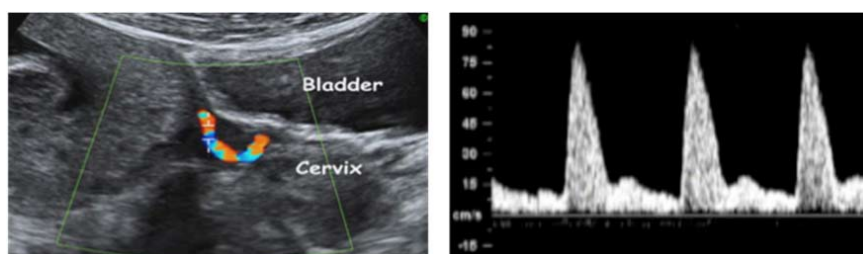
Identification of the uterine artery at the level of the internal os (left) and typical waveforms of the uterine artery Doppler in the first trimester of pregnancy. Courtesy of the Fetal Medicine Foundation. [Colour figure can be viewed at wileyonlinelibrary.com]
